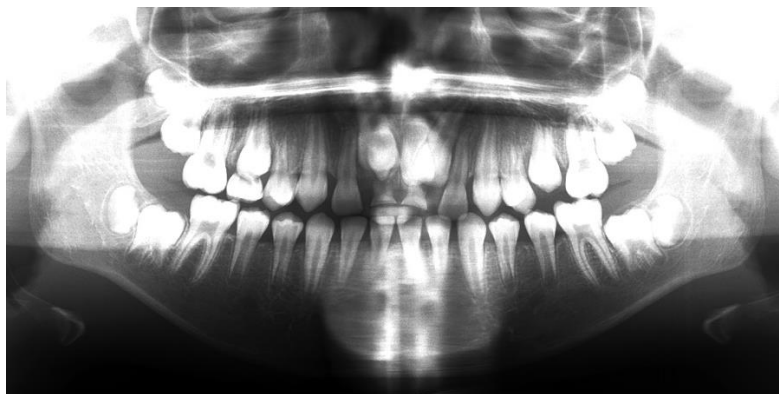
Pre-treatment orthopantomogram revealed two impacted upper central incisors.
